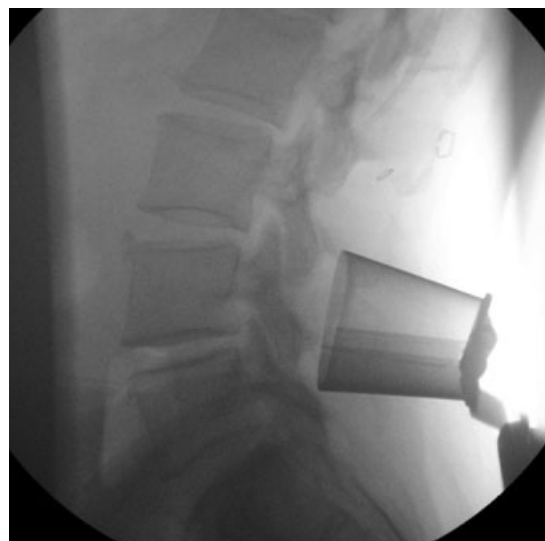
Intraoperative X-ray: tube expander placed in proper position at the L4-L5 level.
